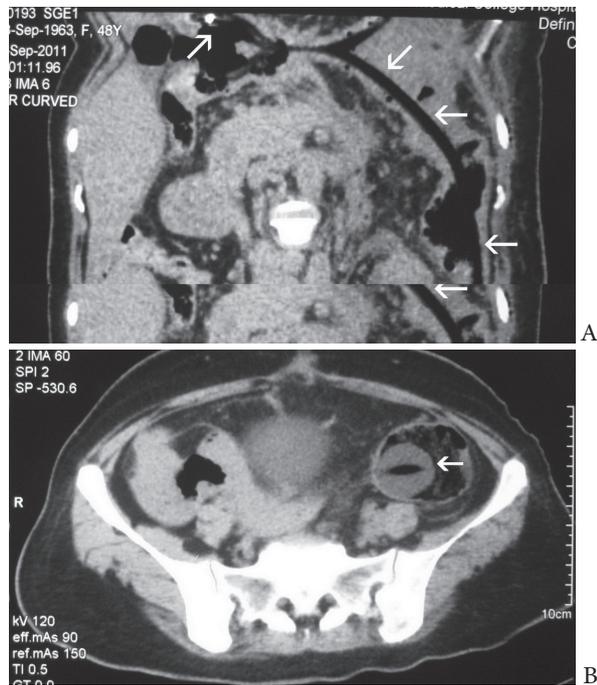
(A) Computed tomography (coronal section, curved reformation) demonstrating the Foley catheter (arrows) intraluminally in its entire length, starting from mid transverse colon and reaching up to sigmoid colon. (B) Computed tomography (axial section) demonstrating the Foley catheter (arrows) intraluminally in descending colon
